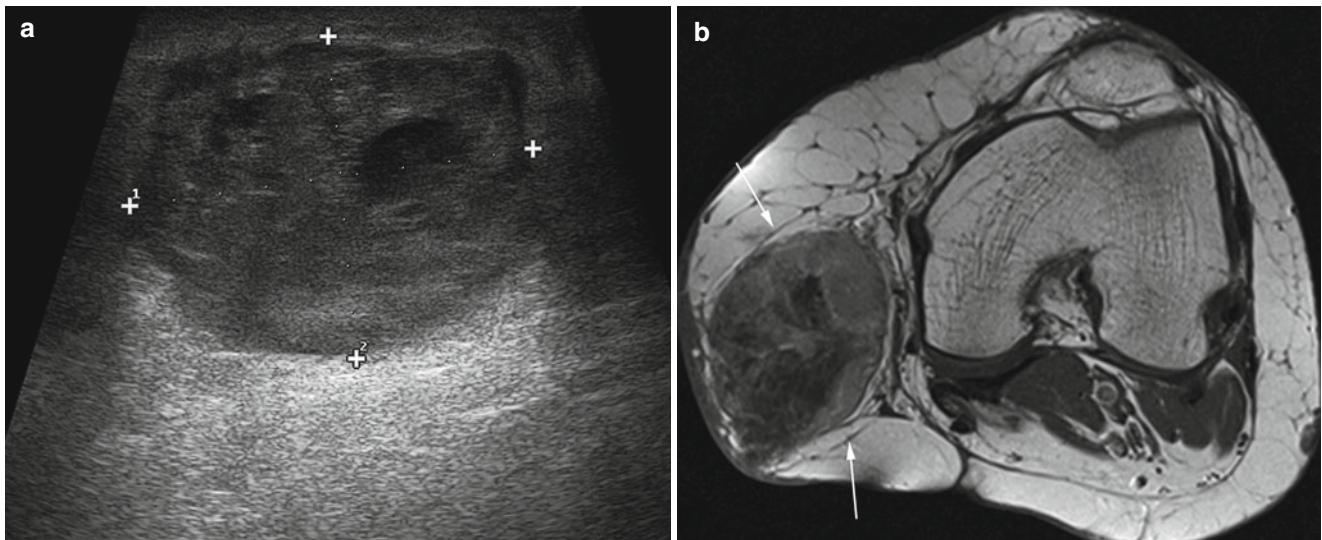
Knee metastasis in a patient with history of cutaneous melanoma in the leg. Ultrasound image shows a partially necrotic, 44 × 35 mm mass (a calipers). The subcutaneous lesion is also evident on the axial magnetic resonance image (b arrows)
